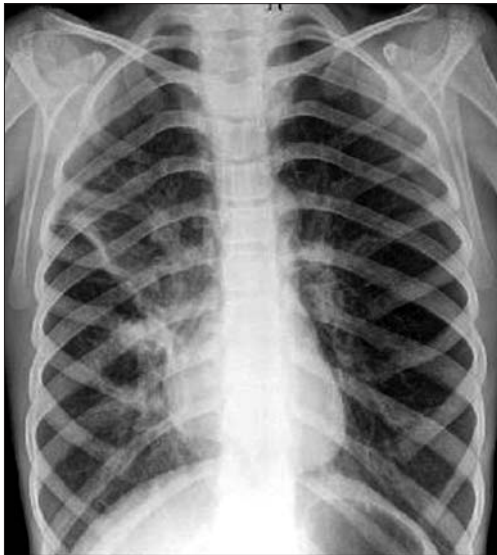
Posteroanterior chest radiograph shows bilateral central peribronchial infiltrations and a linear opacity, consistent with atelectasis, located along with the obliquely oriented minor fissure. Bilateral hila are enlarged.
